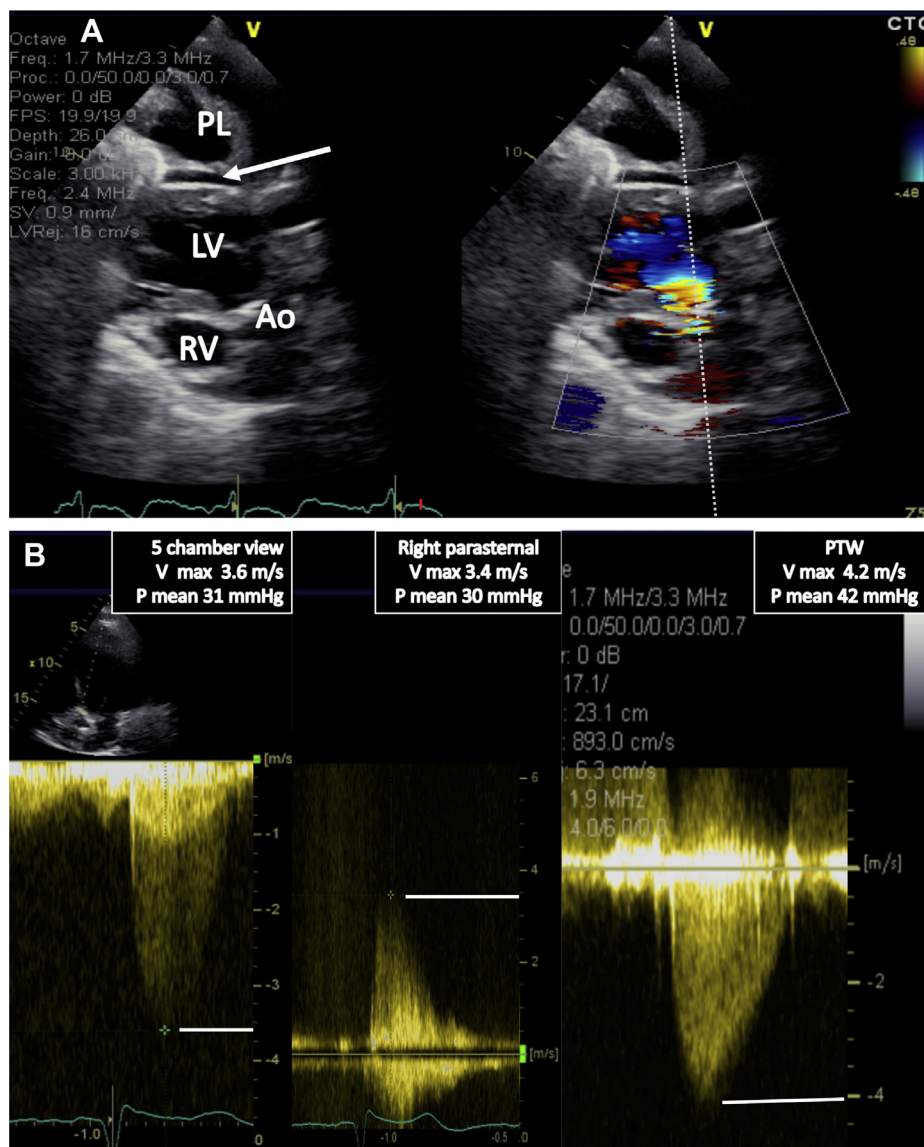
(A) Simultaneous 2-dimensional (left) and color Doppler (right) recording from the posterior thoracic acoustic window showing good beam–jet alignment. Arrow points to a small pericardial effusion. (B) Peak aortic velocity recordings are shown from the apical window (left) and the right parasternal window using a nonimaging pencil probe (middle). Peak velocity recording from the left posterior thoracic window, taking advantage of a large pleural effusion (right). Ao, aorta; LV, left ventricle; PL, pleural effusion; PTW, posterior thoracic window; RV, right ventricle; V, velocity; P, pressure gradient.
